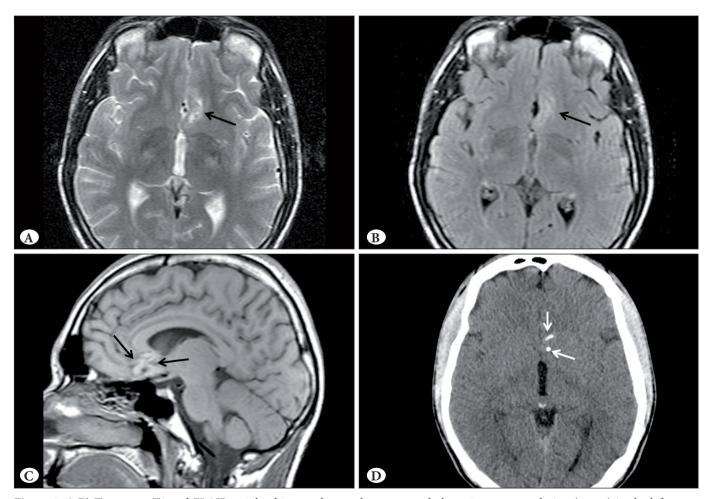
A,B) Transverse T2 and FLAIR weighted image shows a heterogenously hyperintense mass lesion (arrow) in the left gyrus rectus of the left frontal lobe. The abnormal signal is limited to the lesion itself with no associated vasogenic edema. C) Sagittal T1-weighted image shows that mass (arrows) is slightly hyperintense relative to the brain parenchyma. D) Foci of calcification (arrows) within the mass are noted on the plain computed tomography image.
